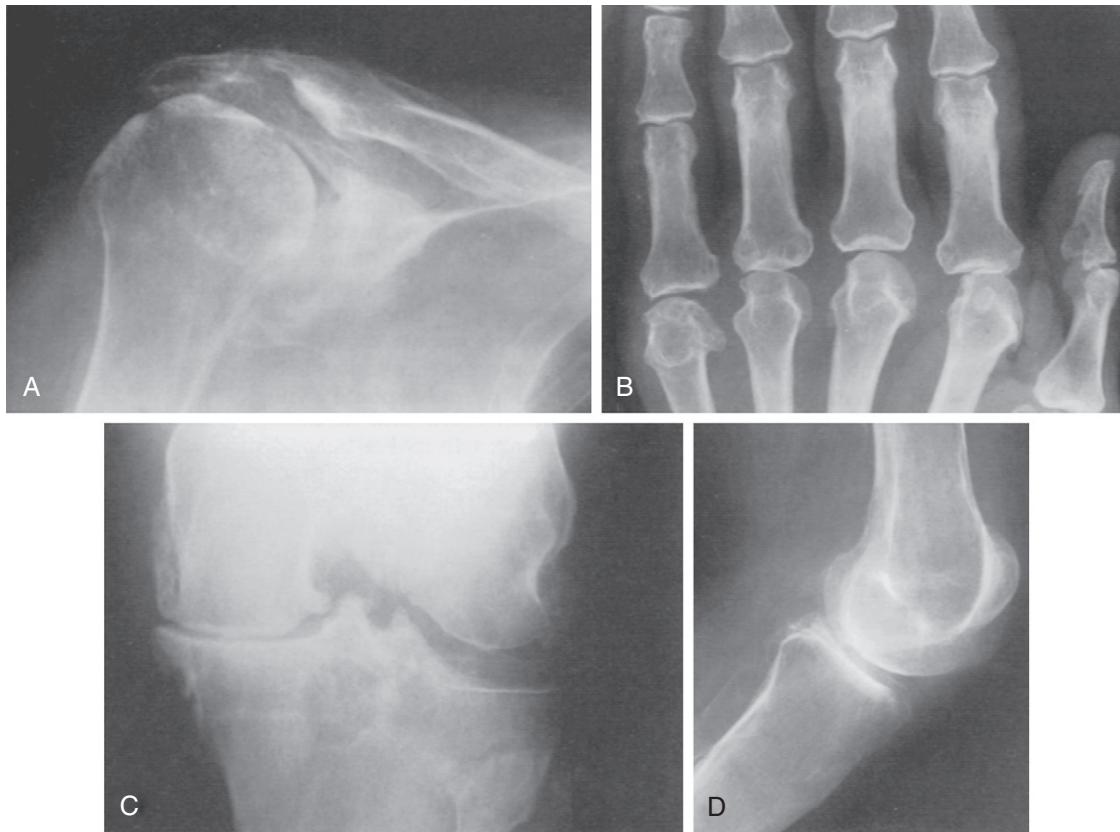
Radiographic features of calcium pyrophosphate dihydrate arthropathy. A, Destructive shoulder arthropathy. B, Metacarpophalangeal joint arthropathy. C, Knee degenerative joint disease with large subchondral bone cyst. D, Wraparound patella (same patient shown in A).
